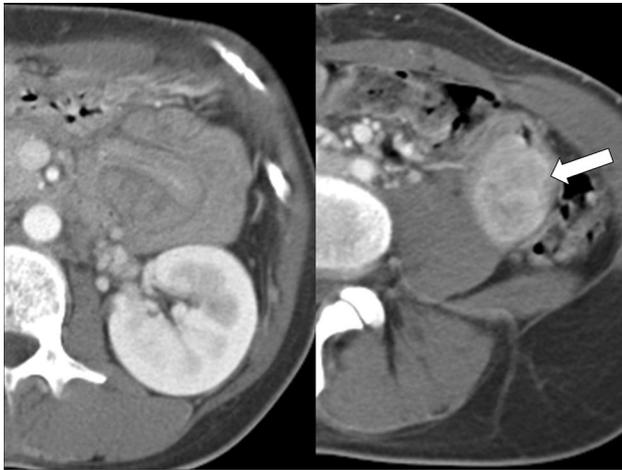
A 35-year-old woman presenting with abdominal. CT axial images show a jejuno-jejunal intussusception at the left abdomen (left). A lobulating, well-enhanced mass is seen in the jejunum as a leading cause (arrow, right). After surgical excision, this mass was confirmed to be a villotubular adenoma with focal high-grade dysplasia in the jejunum
